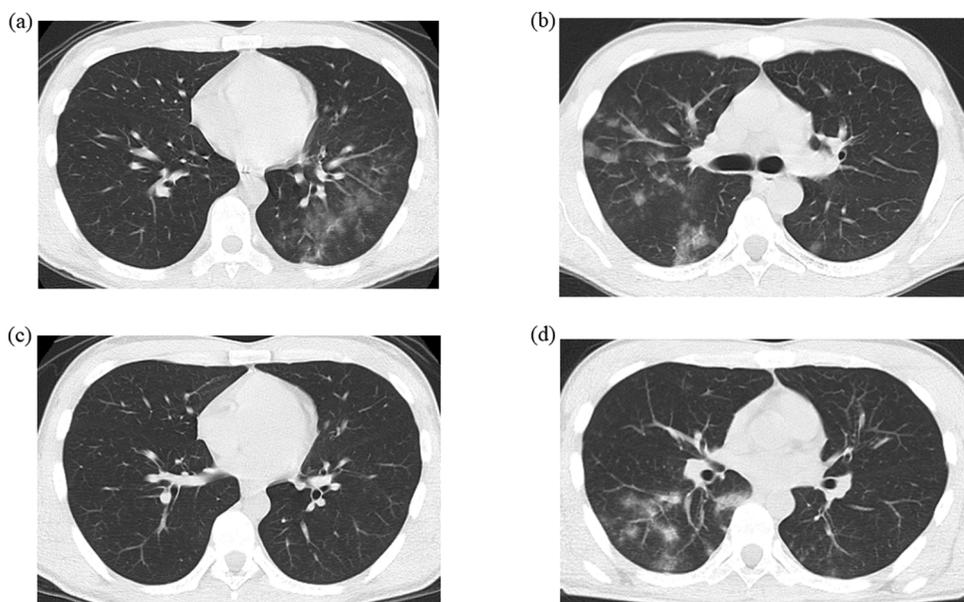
(a) Axial computed tomography (CT) image showed numerous ground glass opacities (GGO) in the left lower pulmonary lobe on day 6. (b) Axial CT image showed patchy GGO in the right pulmonary lobes on day 33. (c) Axial CT image showed no particular findings in both lungs on day 46. (d) Axial CT image showed another patchy GGO in the right lower pulmonary lobe on day 80.
